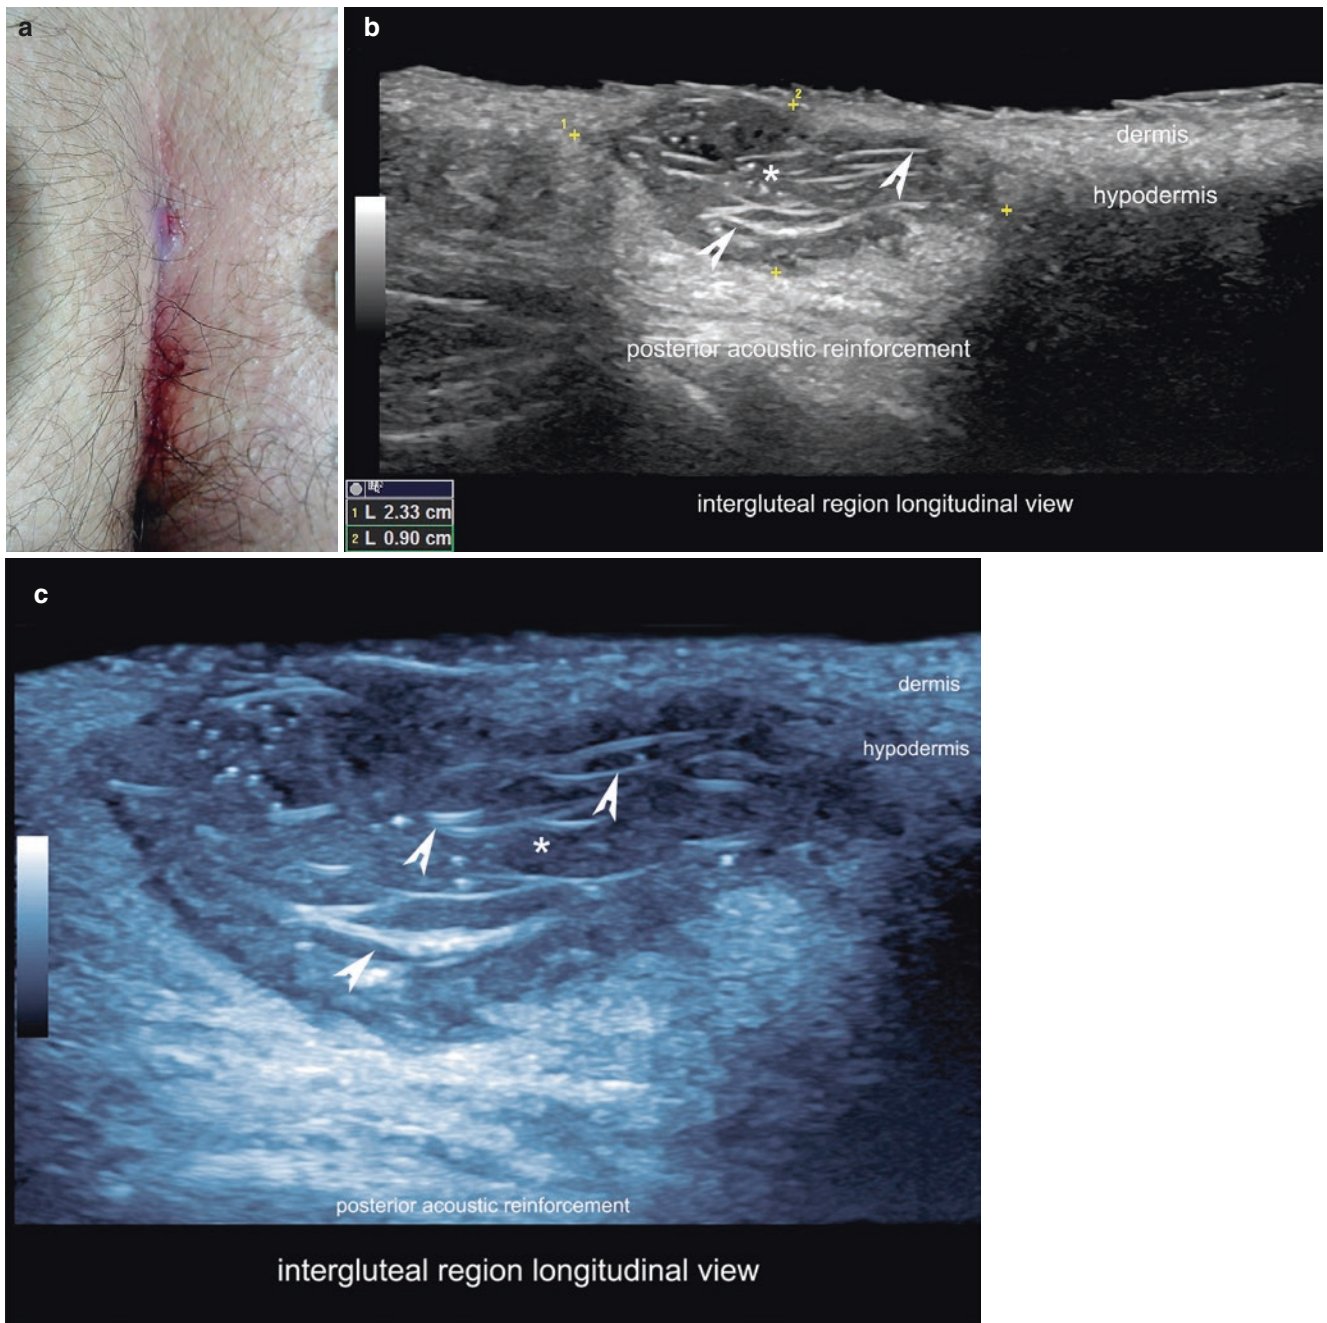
Pilonidal cyst. (a) Clinical image. (b and c), Ultrasound (greyscale, longitudinal view; c with color filter) shows hypoechoic, sac-like dermal and hypodermal structure with multiple hyperechoic
